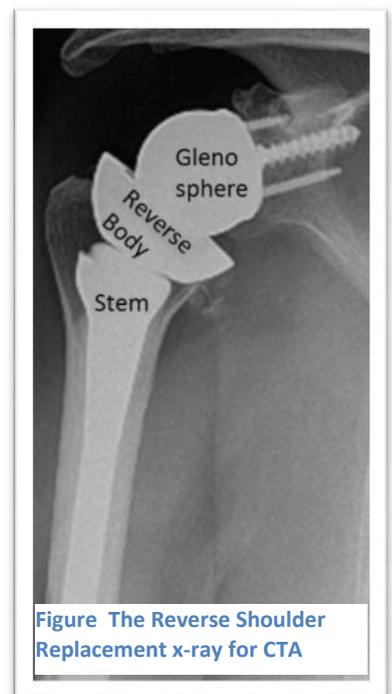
Figure The Reverse Shoulder Replacement x-ray for CTA
